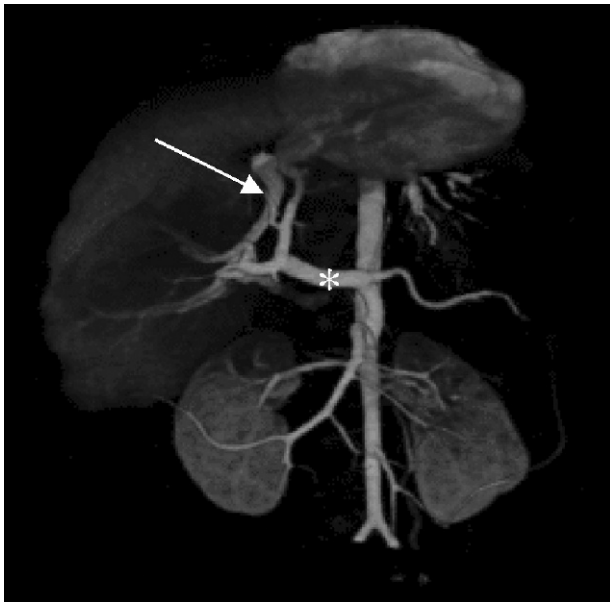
CT angiogram with 3-dimensional reconstruction of child with IAPF at 2 years of age. Markedly enlarged common hepatic artery (asterisk) and left hepatic artery are observed. Early abnormal filling of the left branch of the portal vein is observed (arrow).
